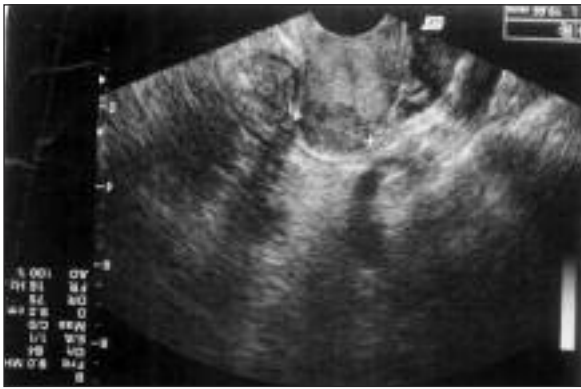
Ultrasound of the remnant cervix.
